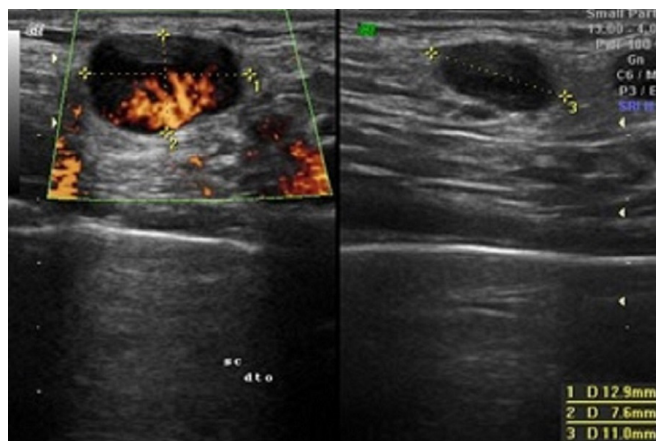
Increased Doppler signal, in the largest nodular structure, suggesting a recently developing adenopathy.
